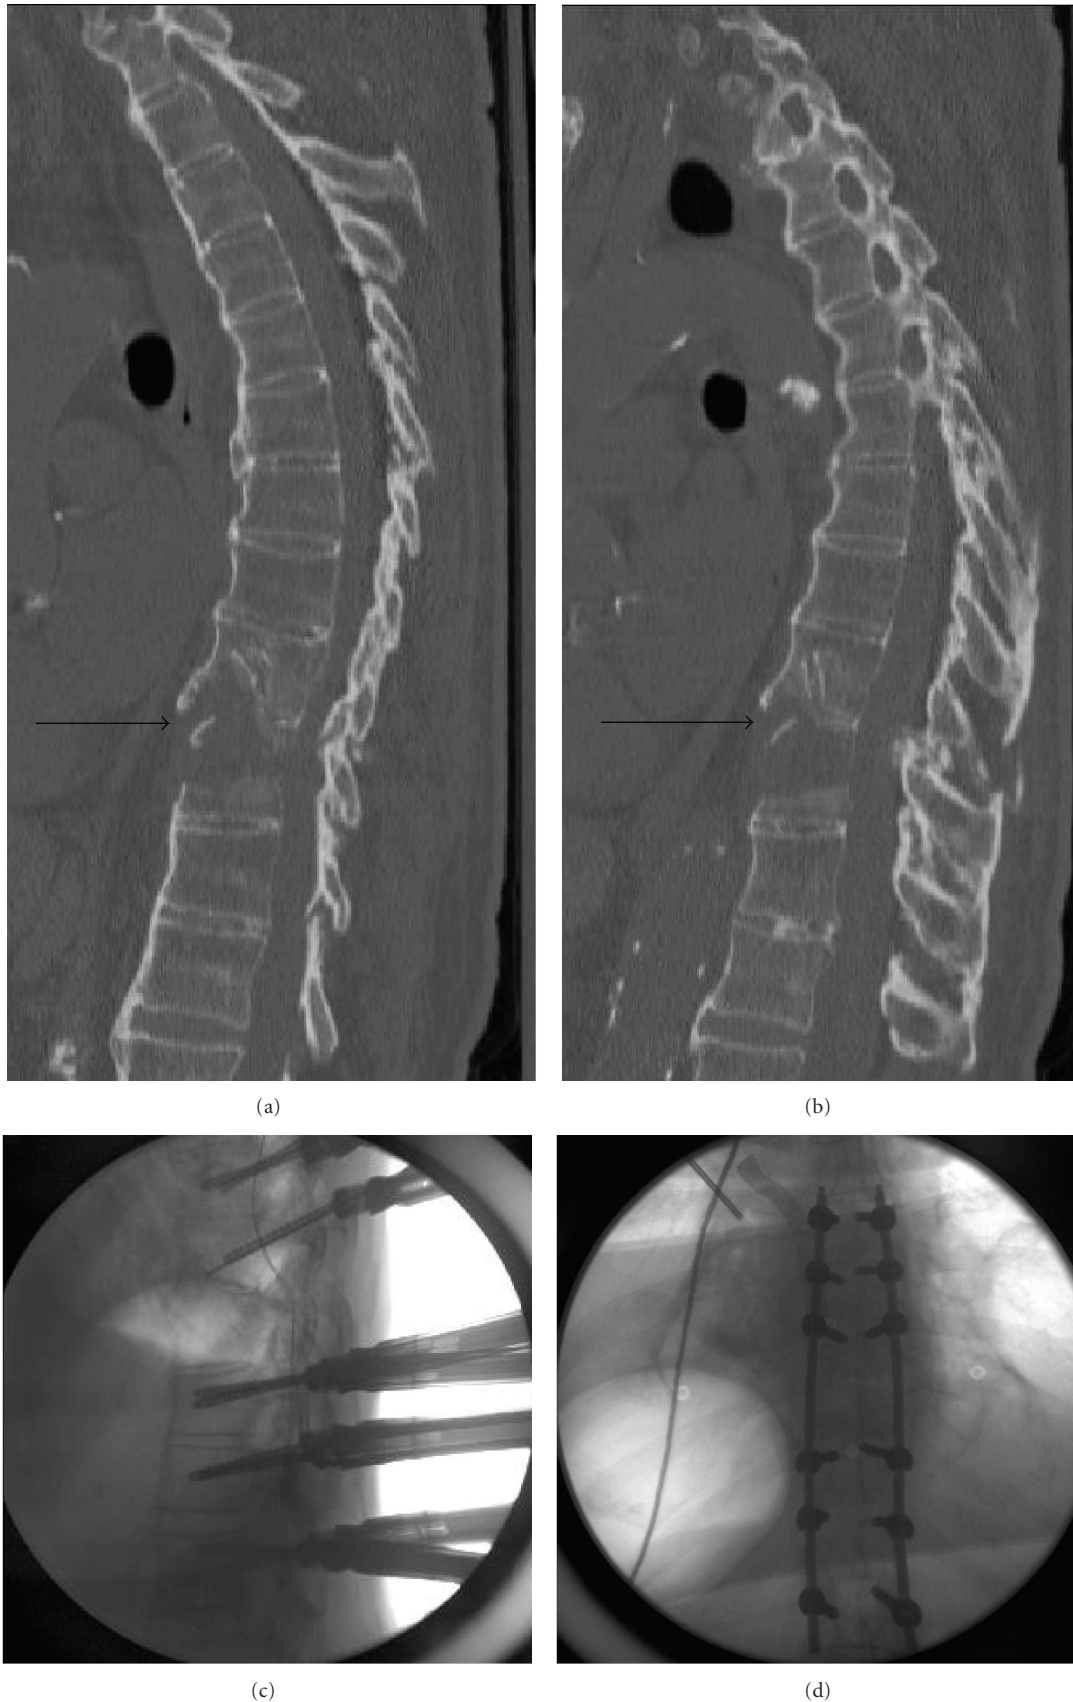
Sagittal computed tomography (a) and (b) of an octogenarian male with a distractive-extension injury through the T9-10 disc (black arrow) with anterior column deficiency due to osteoporosis and fracture extension into posterior elements. Intraoperative lateral (c) and anteroposterior (d) fluoroscopy depicting percutaneous fixation of the unstable thoracic fracture dislocation in an octogenarian with multiple medical comorbidities.
